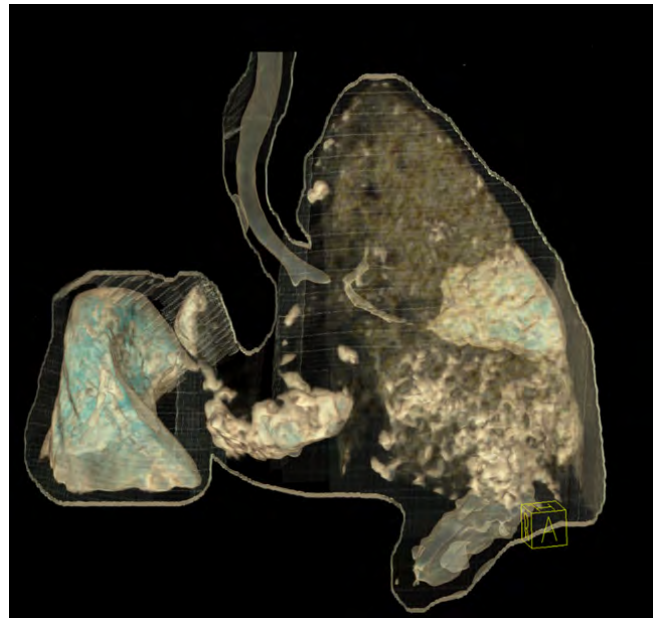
3D reconstruction of CT image shows the left lung having a normal volume. On the contrary, the right lung is not seen with the existing right bronchus having blind-ended branches.
